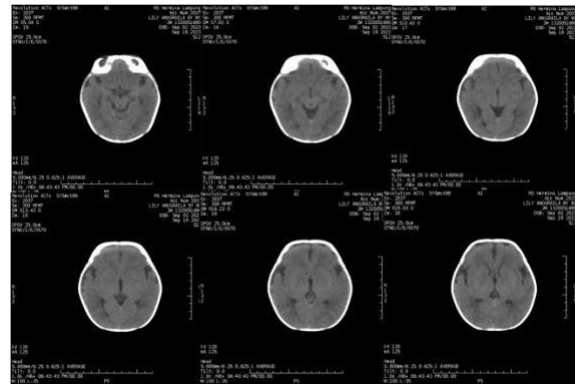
Non-contrast brain CT scan of the patient showing an abnormality
